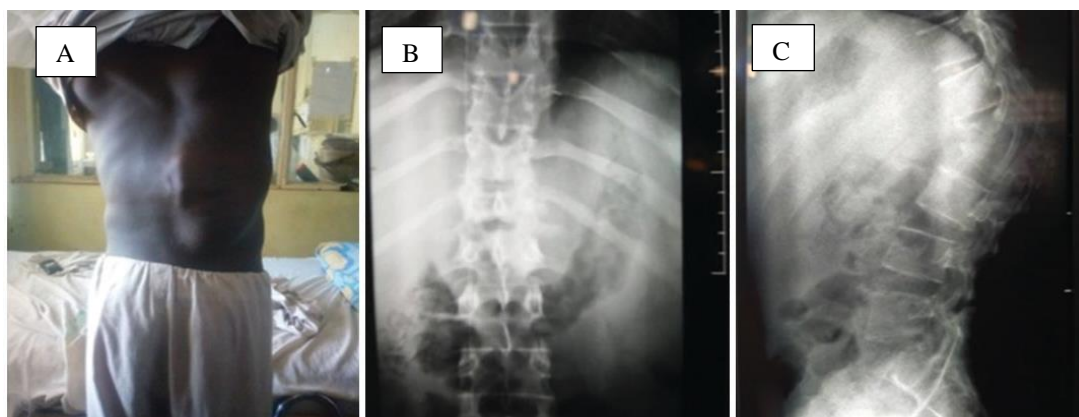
Common clinical features of Pott's disease in Nigeria: (a) a painful thoracolumbar gibbus in a 20 – year – old man with paraspinal cold abscess extending to the right lumbar triangle and paraparesis (b and c) plain x-ray of the same man showing wedge collapse fracture of L2 vertebral body and angular kyphosis [1].
